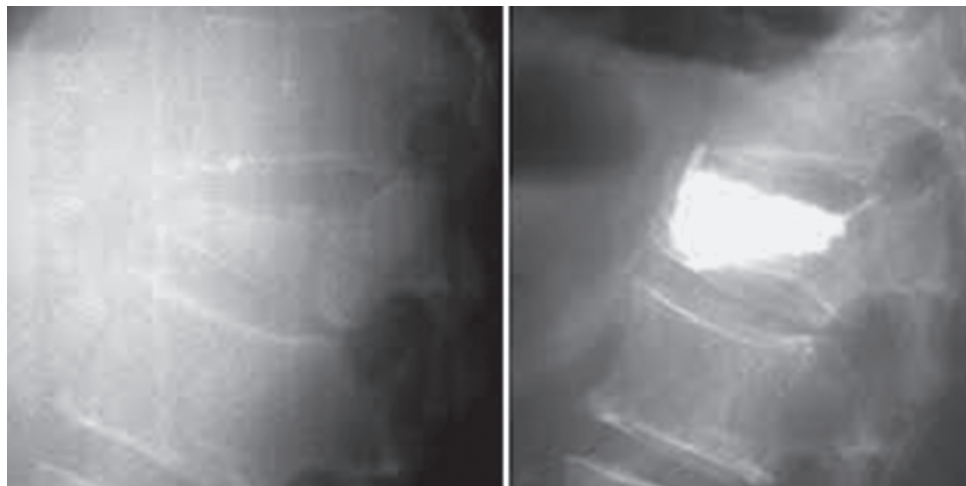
X-ray of lumbar spine
